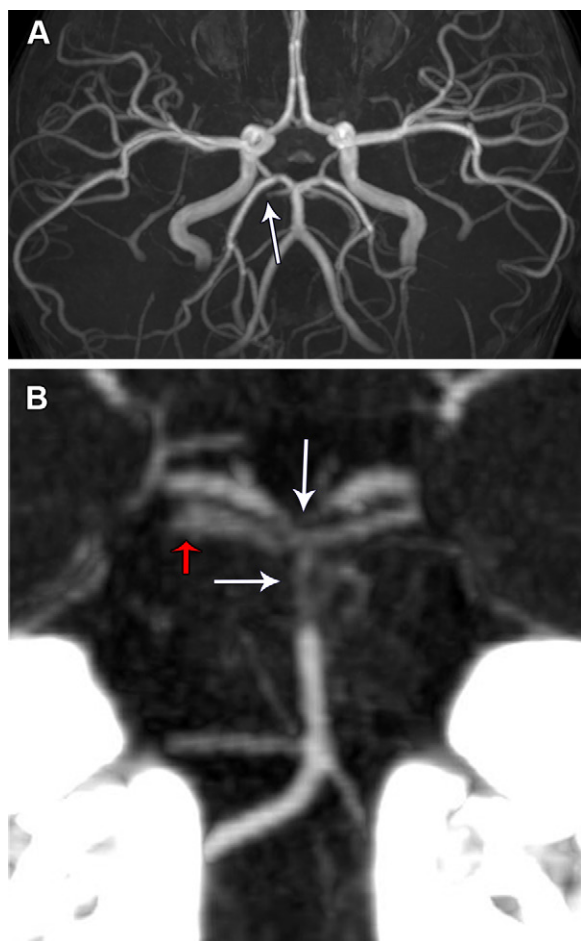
Progressive intracranial arterial occlusive disease due to VAD in a 3-year-old boy with weakness, ataxia, and vomiting. (A) Axial oblique maximum intensity projection (MIP) three-dimensional (3D) time-of-flight (TOF) MR angiogram on day 1 after presentation shows an abrupt occlusion (arrow) of the right superior cerebellar artery. (B) Follow-up coronal MIP CT angiogram on day 6 shows worsening multifocal stenosis and occlusion (white arrows) due to additional vessel-to-vessel thromboembolism and partially recanalized thrombus (red arrow) in the superior cerebellar artery. This finding may be difficult to differentiate from cerebral arteriopathy.
